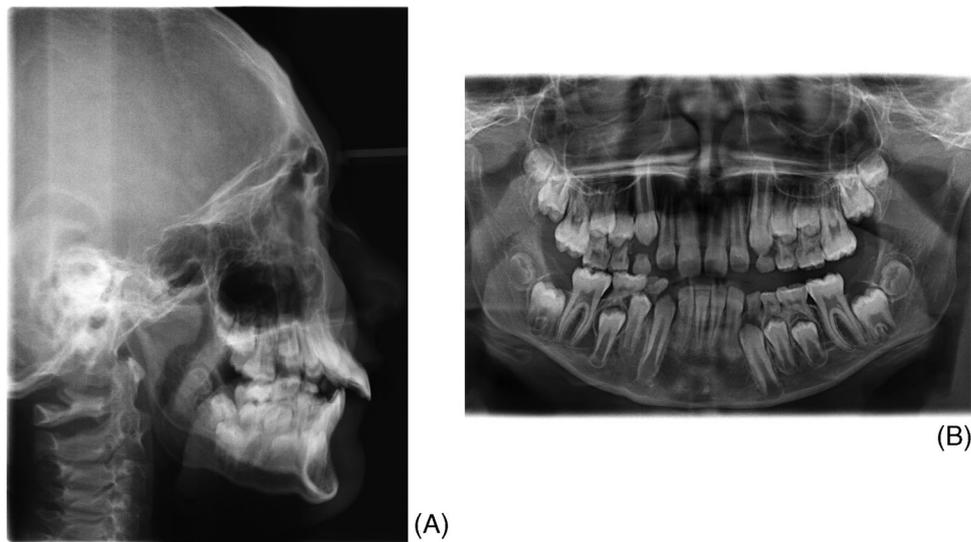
Pretreatment cephalometric (A) and panoramic (B) radiographs
